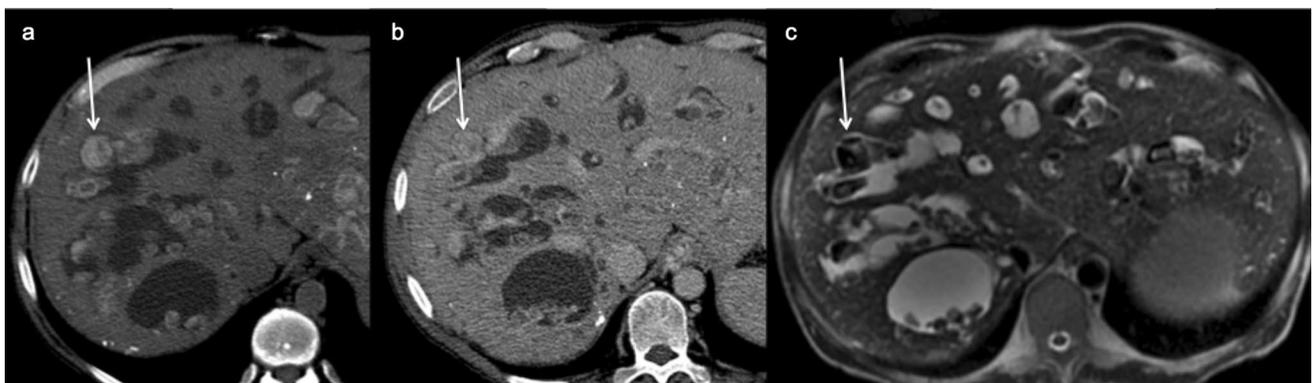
Caroli disease. Axial unenhanced and contrast-enhanced CT images (a, b) and axial T2-w MR image (c) show multiple saccular cystic dilatations of the intrahepatic bile ducts containing multiple stones (white arrows)
